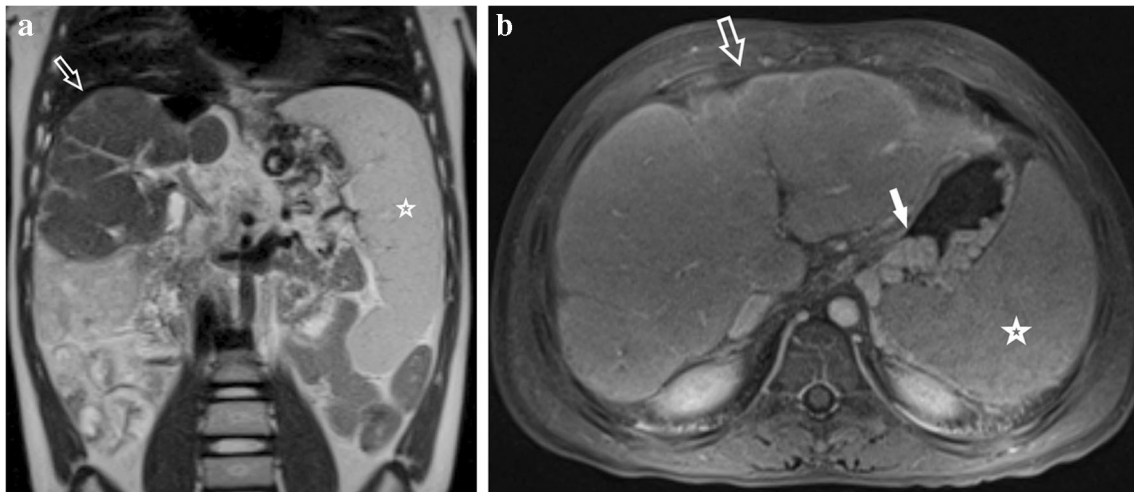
Imaging in an 8-year-old boy with history of biliary atresia, post Kasai procedure. a Coronal half-Fourier acquisition single-shot turbo spin-echo (HASTE) MR image demonstrates a shrunken and nodular liver (*arrow*), compatible with cirrhosis, and splenomegaly (*star*). b
